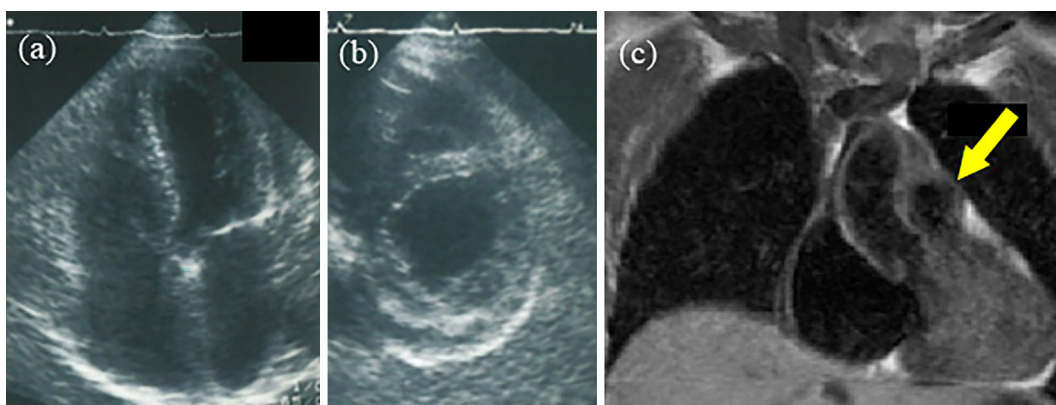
Imaging findings of Case 2. (a, b) Transthoracic echocardiography showed flattening of the interventricular septum by an enlarged right ventricle, along with pericardial effusion. (c) Contrast-enhanced MRI showed enhanced wall thickening and stenosis of the left pulmonary artery without thrombosis (arrow).
